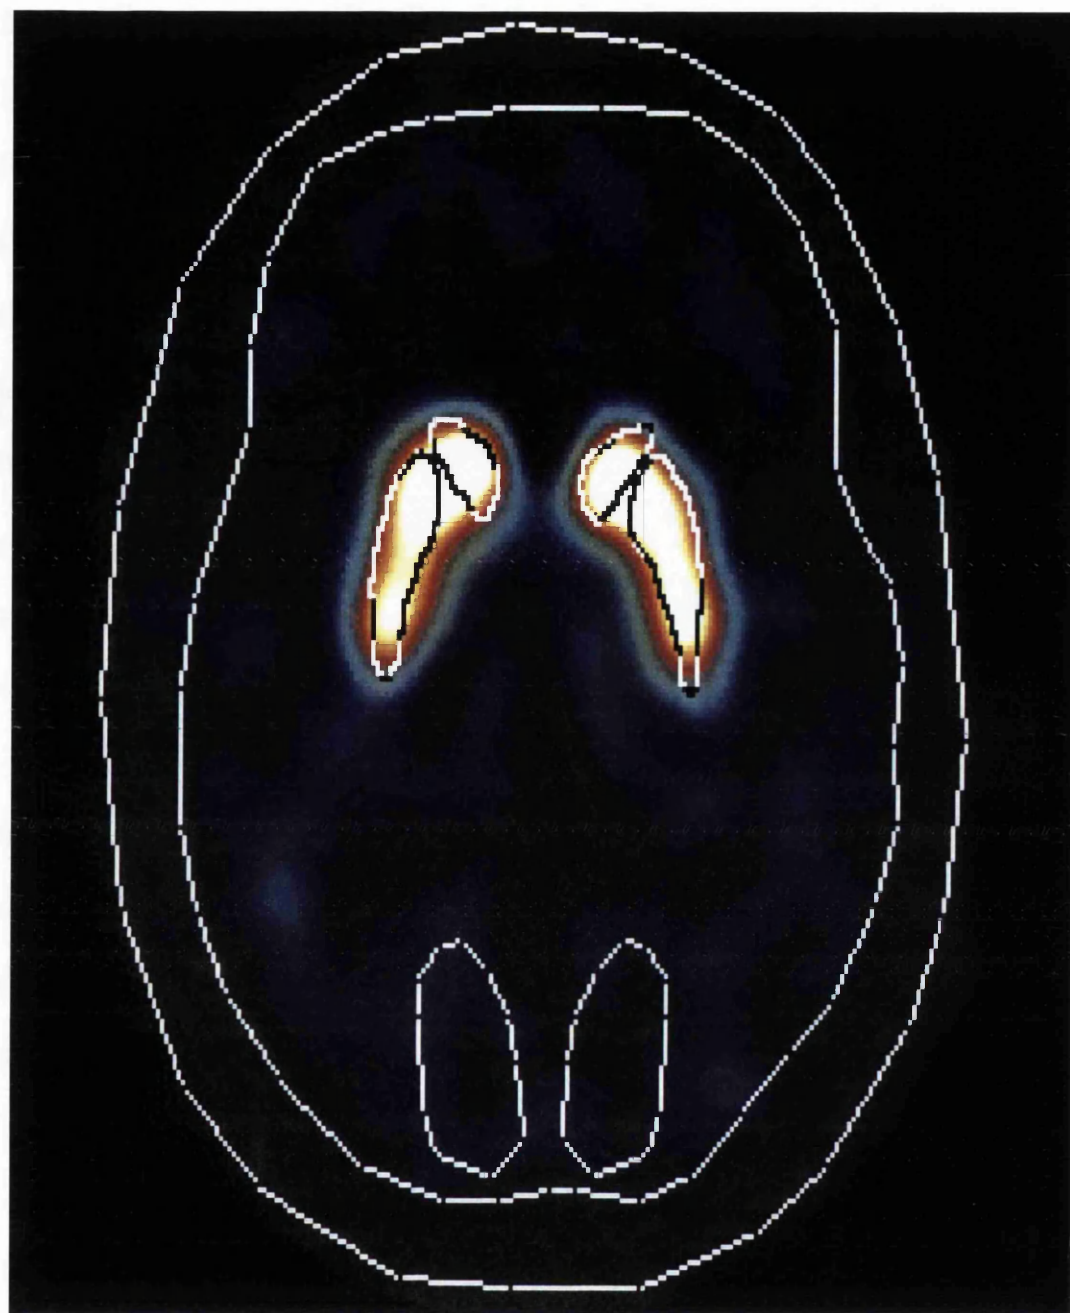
Applications of region of interest to SPECT imaging showing right and left caudate, putamen and occipital regions, as well as the whole head and the brain.
